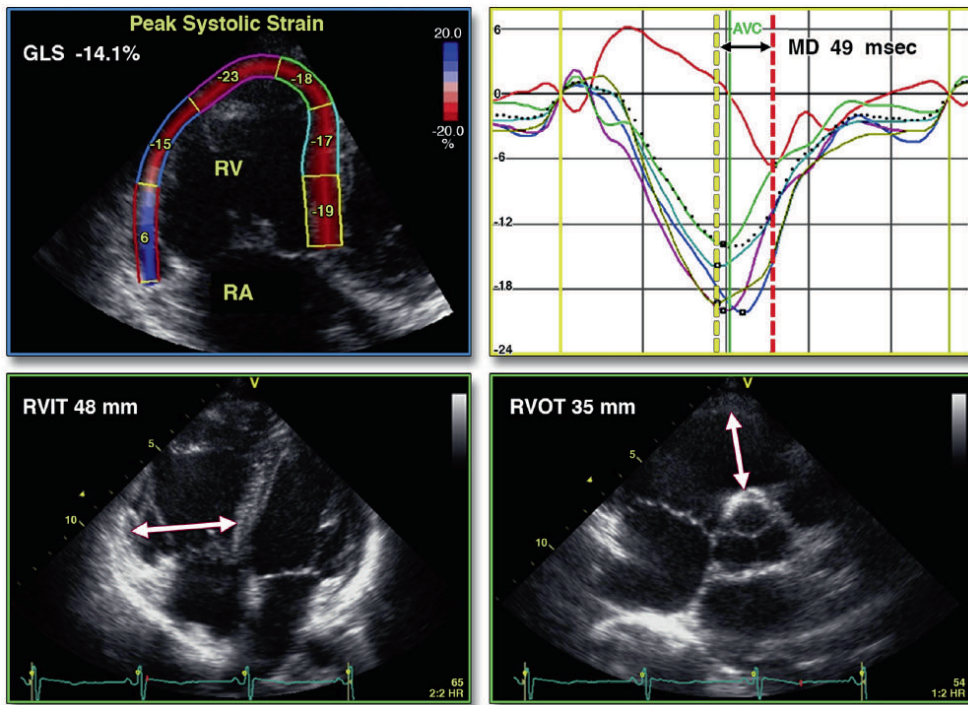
Proposed Echocardiographic Measurements During Follow-up
